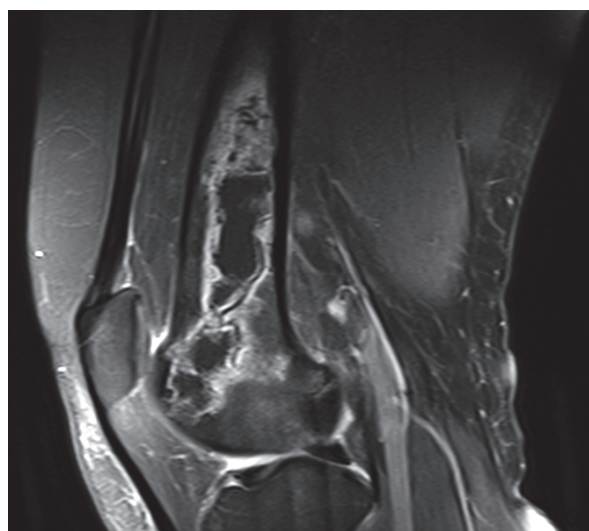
Knee osteonecrosis on coronal T2-weighted images after intraarticular corticosteroid and local anesthetic injection.
